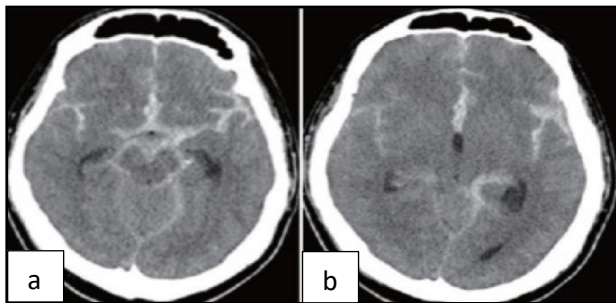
(a and b): Non-contrast CT brain revealed SAH.
